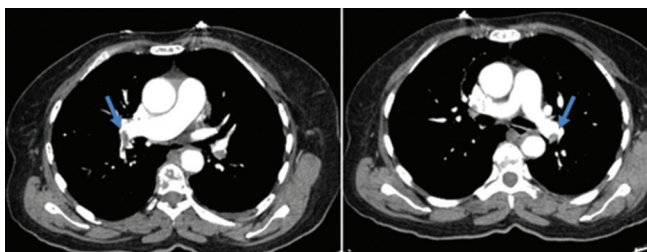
Thorax computed tomography scans showing thrombus formation in both main pulmonary arteries
